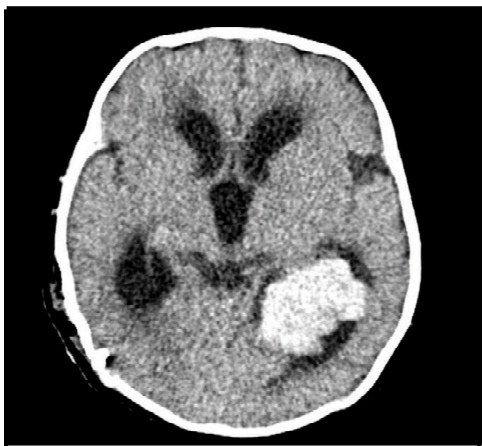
CT scan-large heterogeneous density mass with lobulated mass with an isointense signal relative to white matter and significant periventricular edema in the right lateral ventricle
